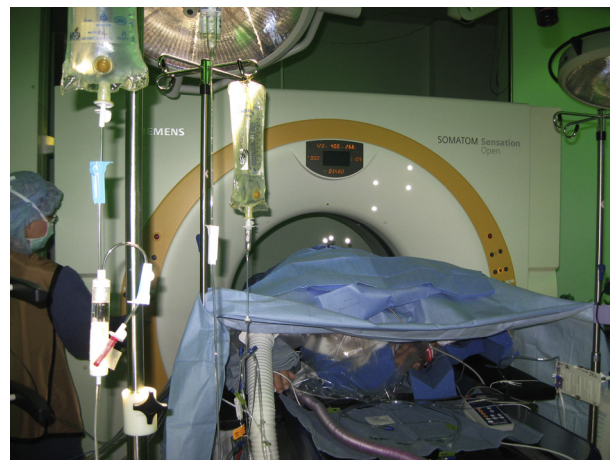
Lumbar patient in CT scanner during procedure. Patient is prone going feet-first into the scanner. The reflective markers attached to the patient and scanner can be seen as they are identified by the infrared tracking system.
